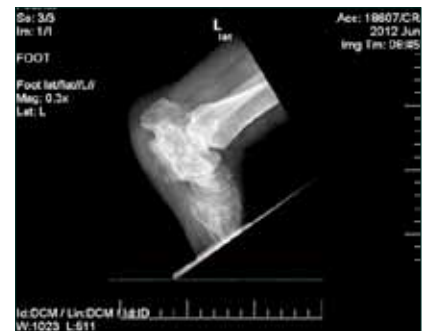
X-ray of the left foot 8 months post fracture.
